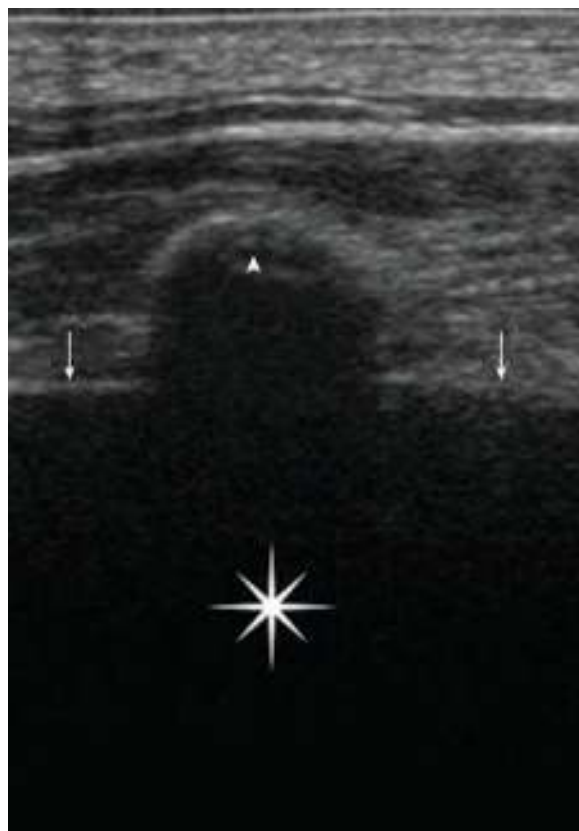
Ultrasound image of a normal lung. Visualized from top to bottom are the subcutaneous tissues, muscle (M), rib shadow (arrowhead), and pleural line (arrows).
